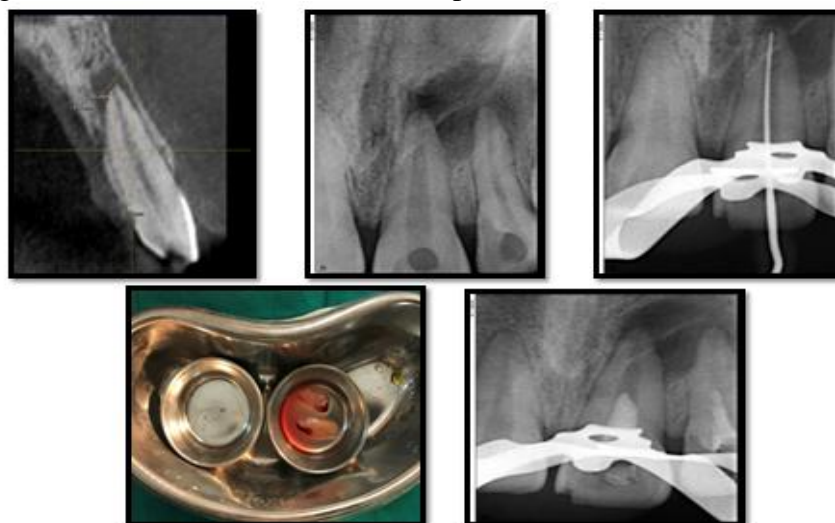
(a,b,c,d): Showing pre-op CBCT, pre-op radiograph, working length, PRF, Insertion of PRF respectively.
